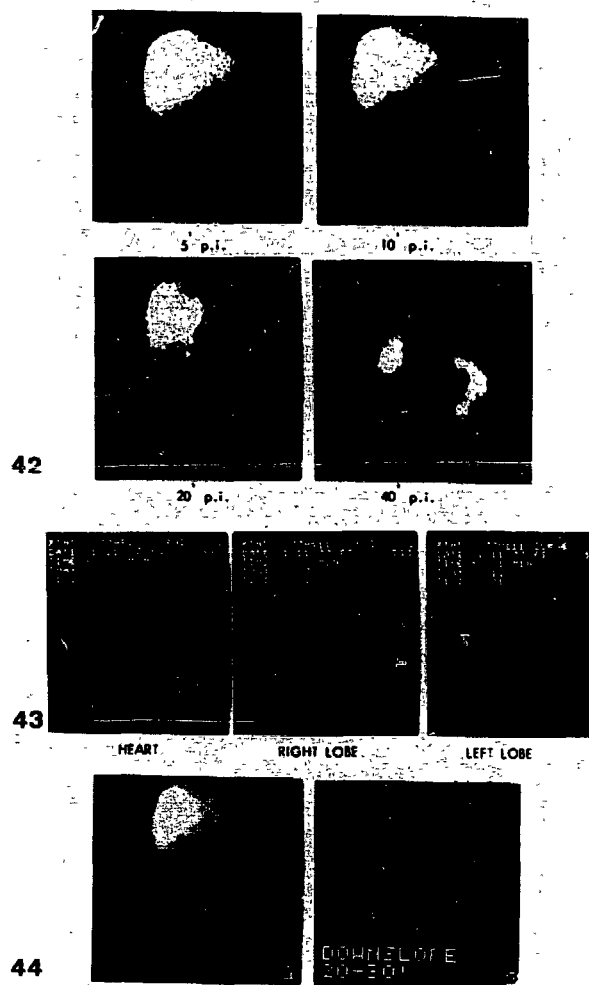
42-44 Cholescintigraphy in a patient with drug induced hepatitis.
